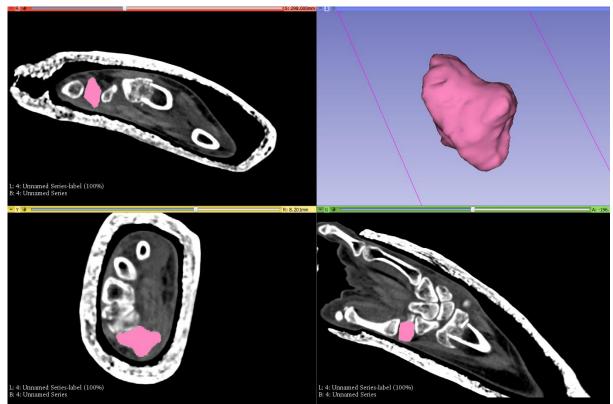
Label map of CT wrist and 3D surface model of trapezium created on 3D slicer.
